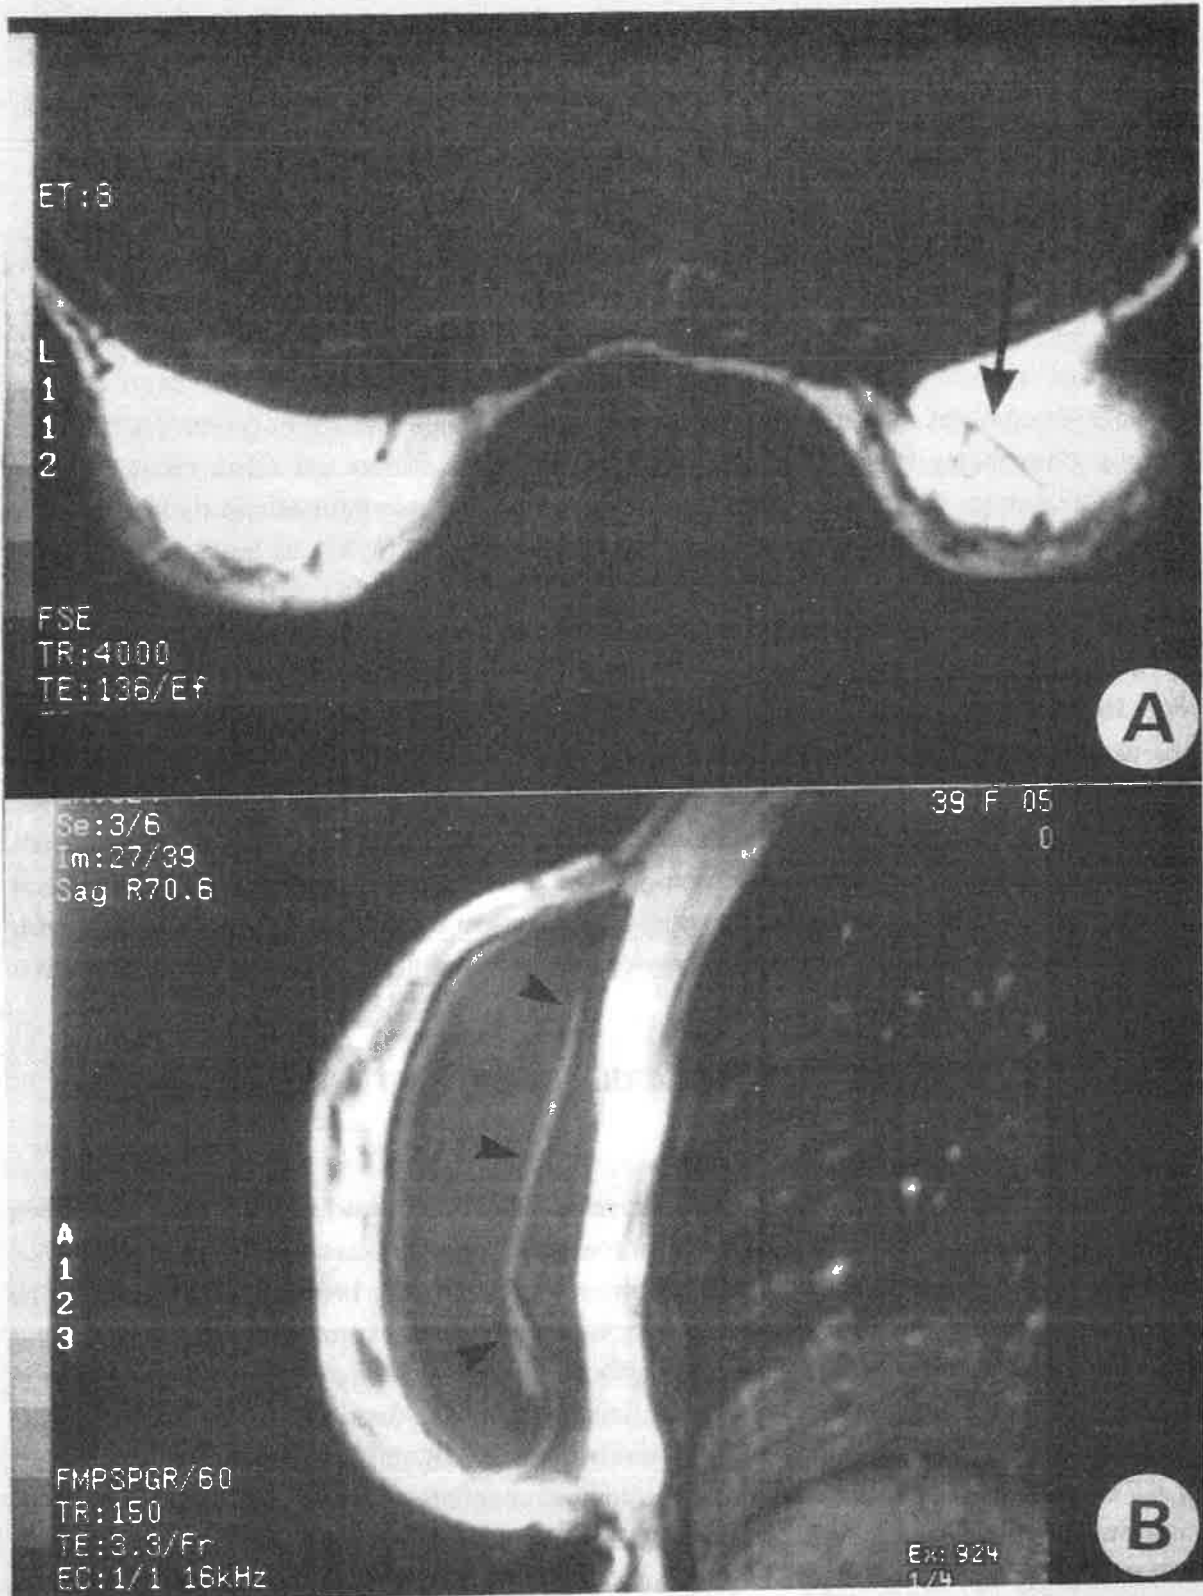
MRI breast examination of a middle-aged patient implanted with gel-filled polyurethane-coated breast prostheses for five years. A. An axial view of both breasts acquired with a fast spin-echo sequence. The left breast is contracted and an intracapsular fold of the left prosthesis is indicated (arrow), whereas the contralateral breast appears normal (TR = 4000 msec, TE = 136 msec). B. A gradient-echo MR image of the left breast of the same patient. Again, the folded prosthesis envelope is apparent (TR = 150 msec, TE = 3.3 msec).
